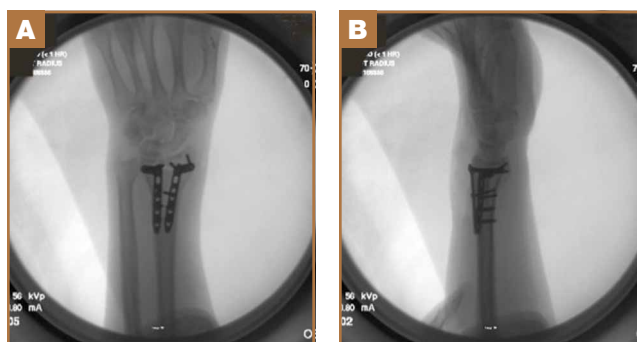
(A) Anteroposterior and (B) lateral radiographs show final product with pins removed.
